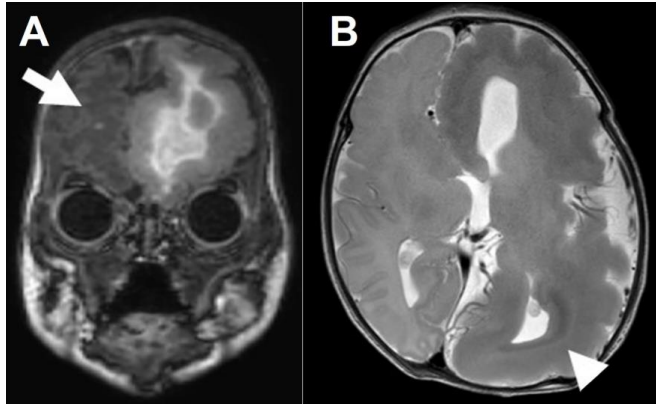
Brain magnetic resonance imaging at 5 days after birth (post-conceptual age 38 weeks and 0 days). (A) Coronal view of T1-weighted image. The arrow indicates a tuber. (B) Axial view of T2-weighted image. The arrowhead indicates band heterotopia associated with hemimegalencephaly. Midline deviation to the right is also noted.
